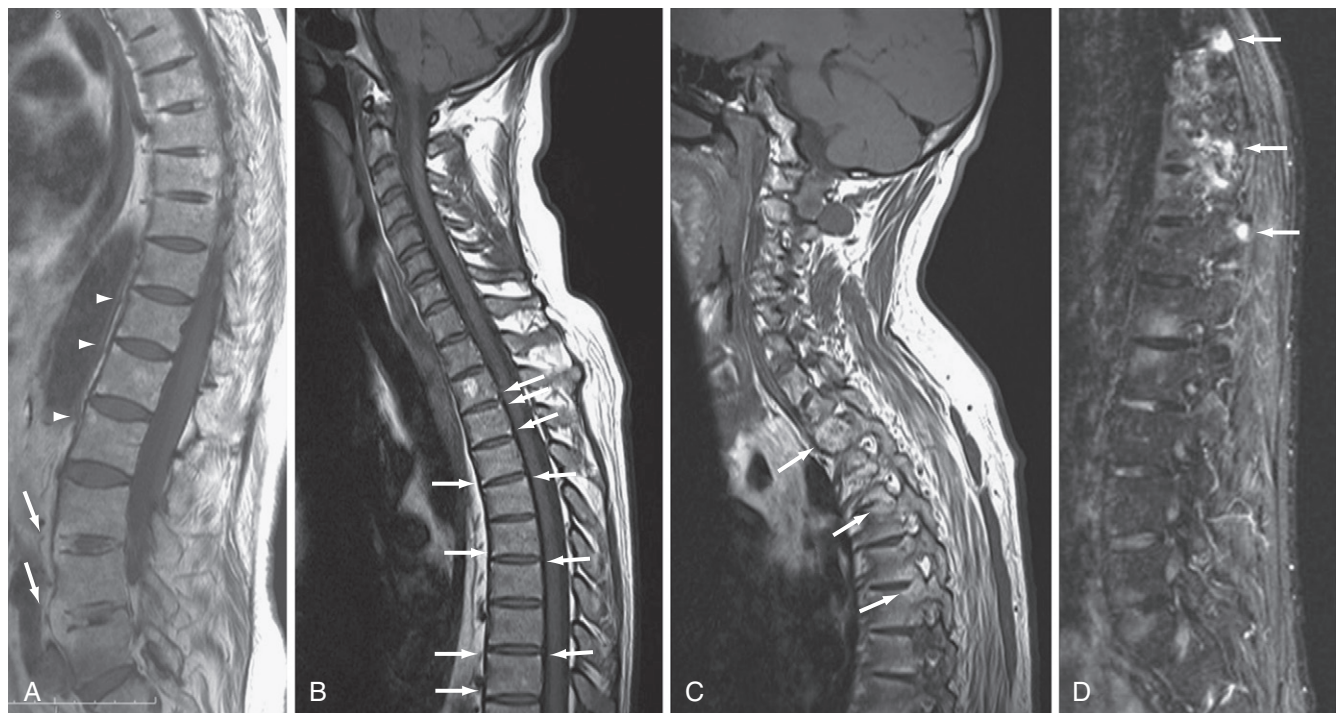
The spine in ankylosing spondylitis (AS) (magnetic resonance imaging [MRI]). A through C, T1-weighted sagittal MRI of three different patients with AS shows different structural lesions. A, Fat infiltration (arrowheads) in the bone marrow of several lumbar vertebral corners and anterior fusion (arrows) at L3-L4 and L4-L5. B, Fatty infiltration (arrows) in the bone marrow of multiple vertebral corners in the cervical spine, indicative of the diagnosis of spondyloarthritis. C, Extensive increased marrow fat signal (arrows) crossing the costovertebral joints (thoracic ankylosis) is seen, as are changes in several facet joints and other posterior elements. D, Sagittal short tau inversion recovery MRI shows intense inflammation in the bone marrow of the transverse processes and facet joints of the lower thoracic spine (arrows), as well as less intense inflammation in several discovertebral joints.
